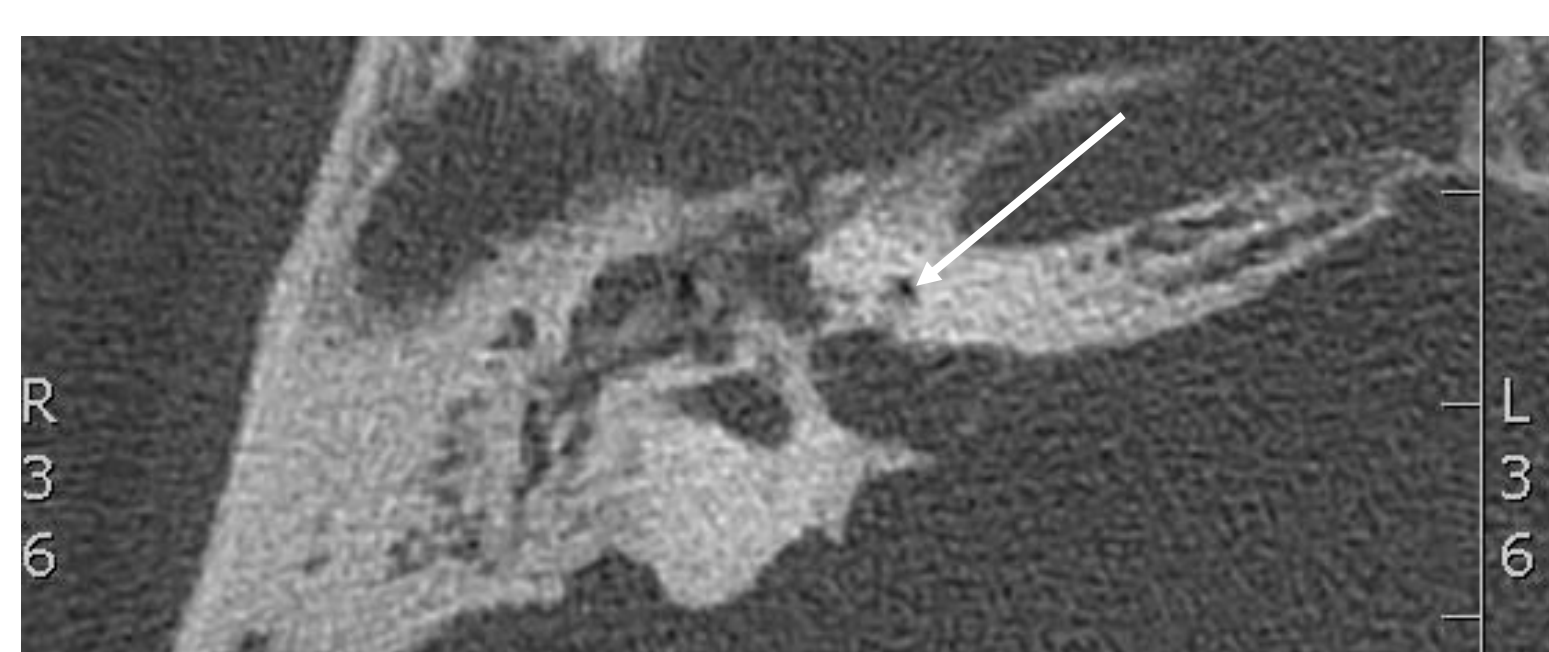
Axial CT of patient 1. Neo-ossification around geniculate, and cochlear ossification (arrow) is seen.
